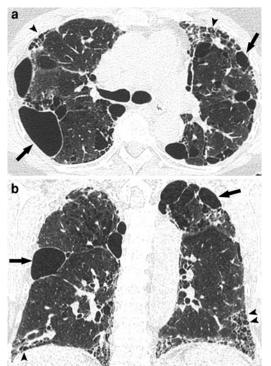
Combined pulmonary fibrosis and emphysema. Transverse (a) and coronal reformatted (b) HRCT images show upper lobe predominant bullous emphysema (*arrows*) and basal predominant subpleural honeycombing (*arrowheads*)
